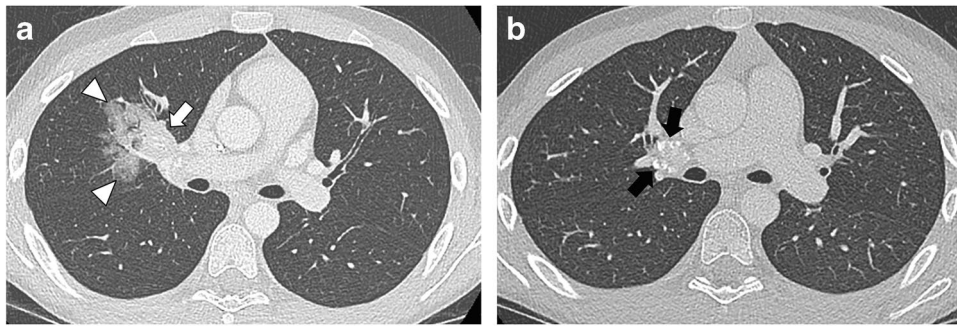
Reactivation histoplasmosis in an 11-year-old boy with osteosarcoma of the humerus on week 9 of chemotherapy. He presented with mild upper respiratory symptoms, fever and neutropenia. a Axial CT image shows a right hilar mass (*arrow*) with adjacent intraparenchymal ground-glass opacities (*arrowheads*). b Axial CT image shows central calcifications (*arrows*) within the hilar mass. Because the parenchymal
